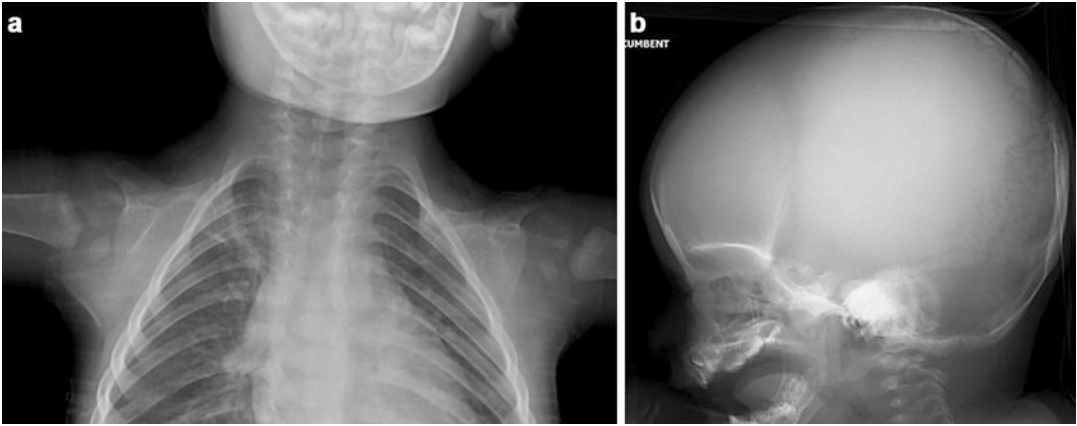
(a, b) A 10-month-old female was seen with a large fontanel and absent clavicles. Her mother, maternal grandfather, and maternal uncle are known to have cleidocranial dysplasia. Chest X-ray showed absent bilateral clavicles (a).
